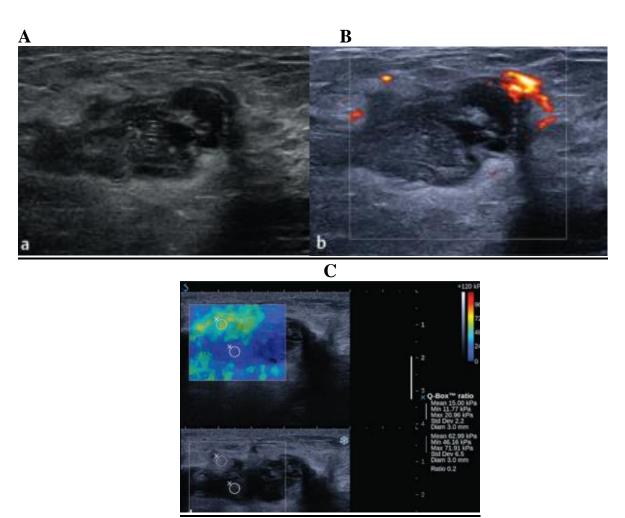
(A): B-mode image of the palpable mass demonstrates a 4 cm irregular, heterogeneous mass corresponding to the mammographic abnormality. (B): On power Doppler imaging there is peripheral
